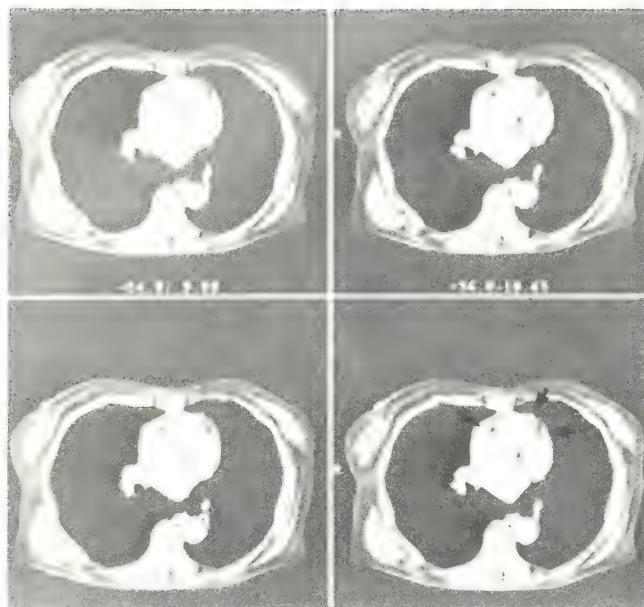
Cine-CT Study of patent coronary bypass grafts (arrow).
